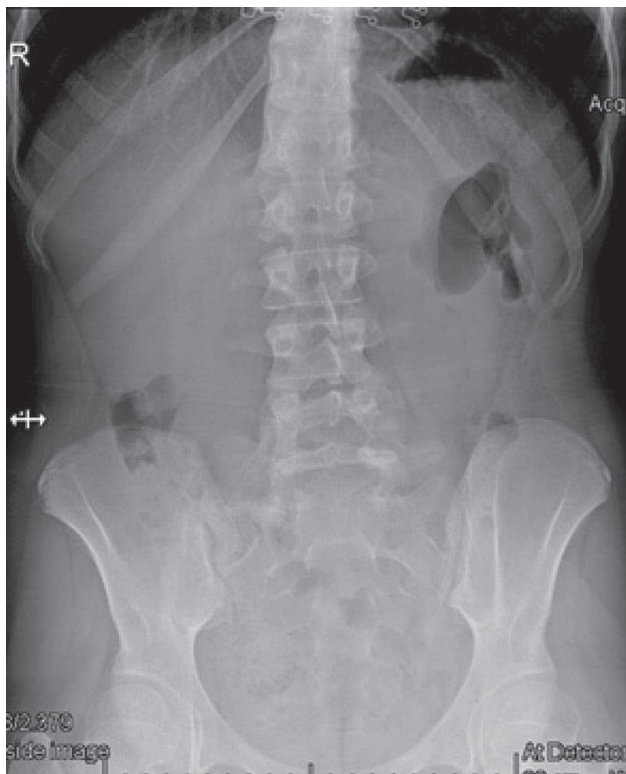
Preoperative normal abdominal x-ray.
